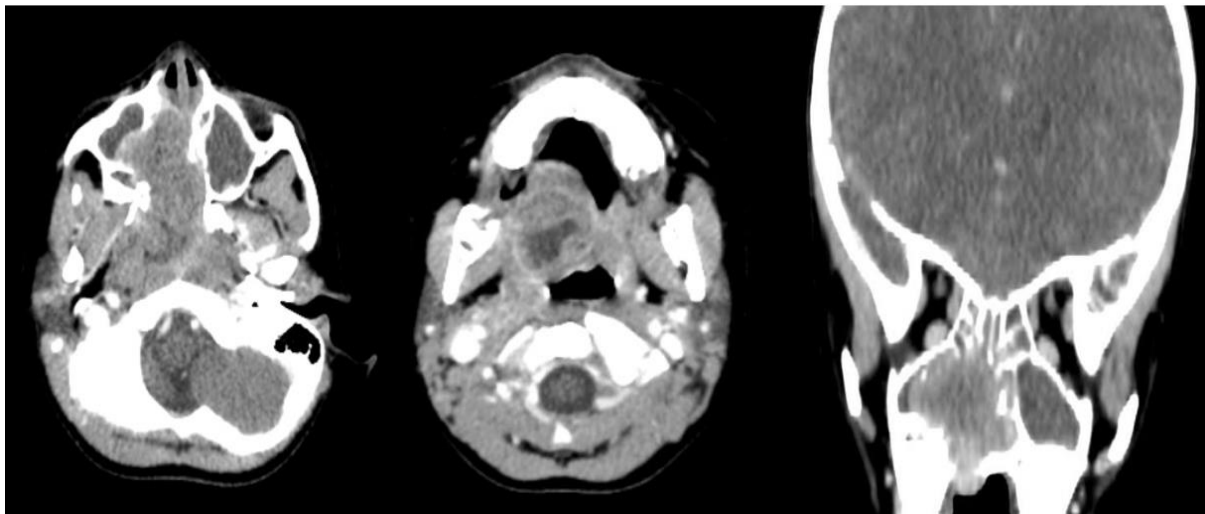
Axial CT scan showing a tissular process centered on the right maxillary sinus extending to the homolateral parapharyngeal space
